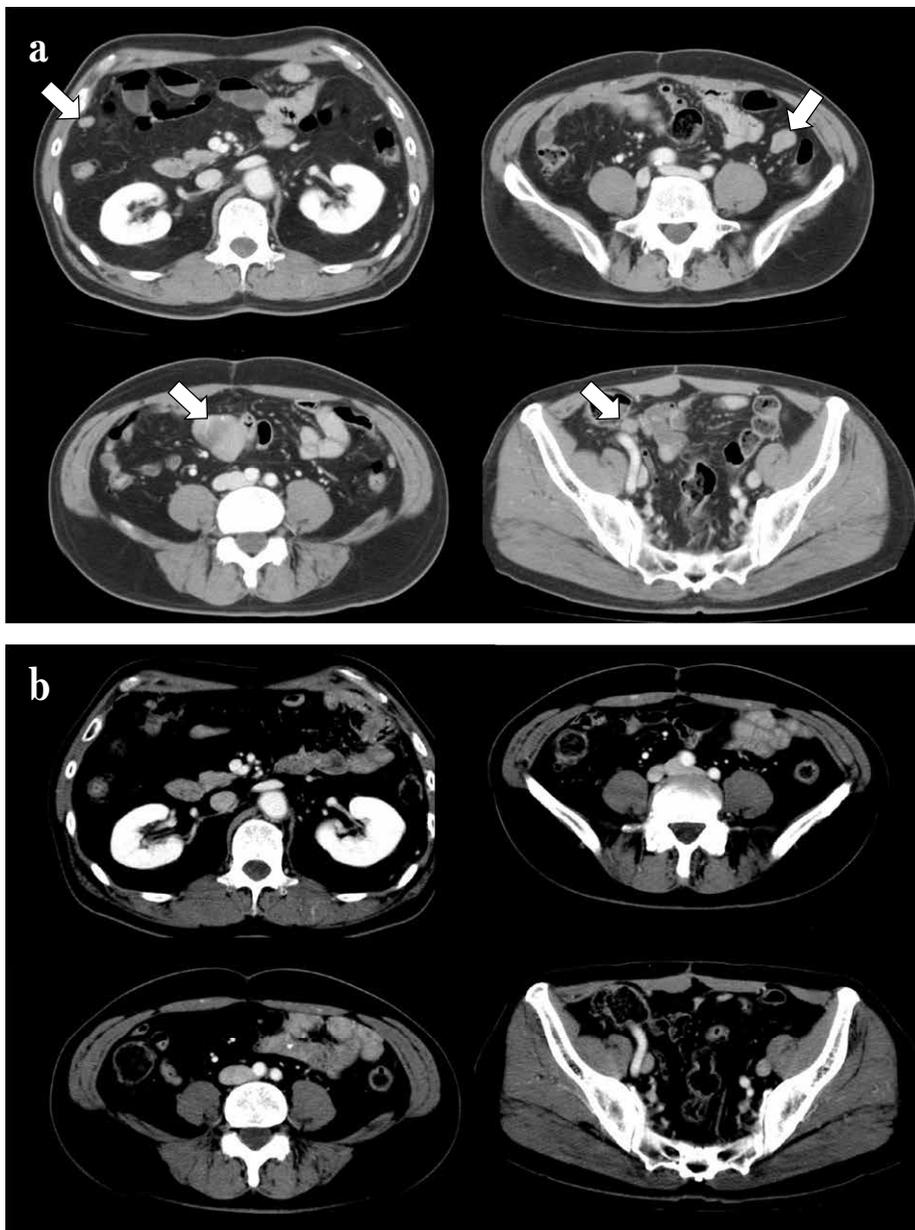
(a) 17 months after operation, another disseminated tumors (white arrows) was detected by follow-up CT. (b)The dissemination was diminished after three months re-challenged imatinib therapy.
